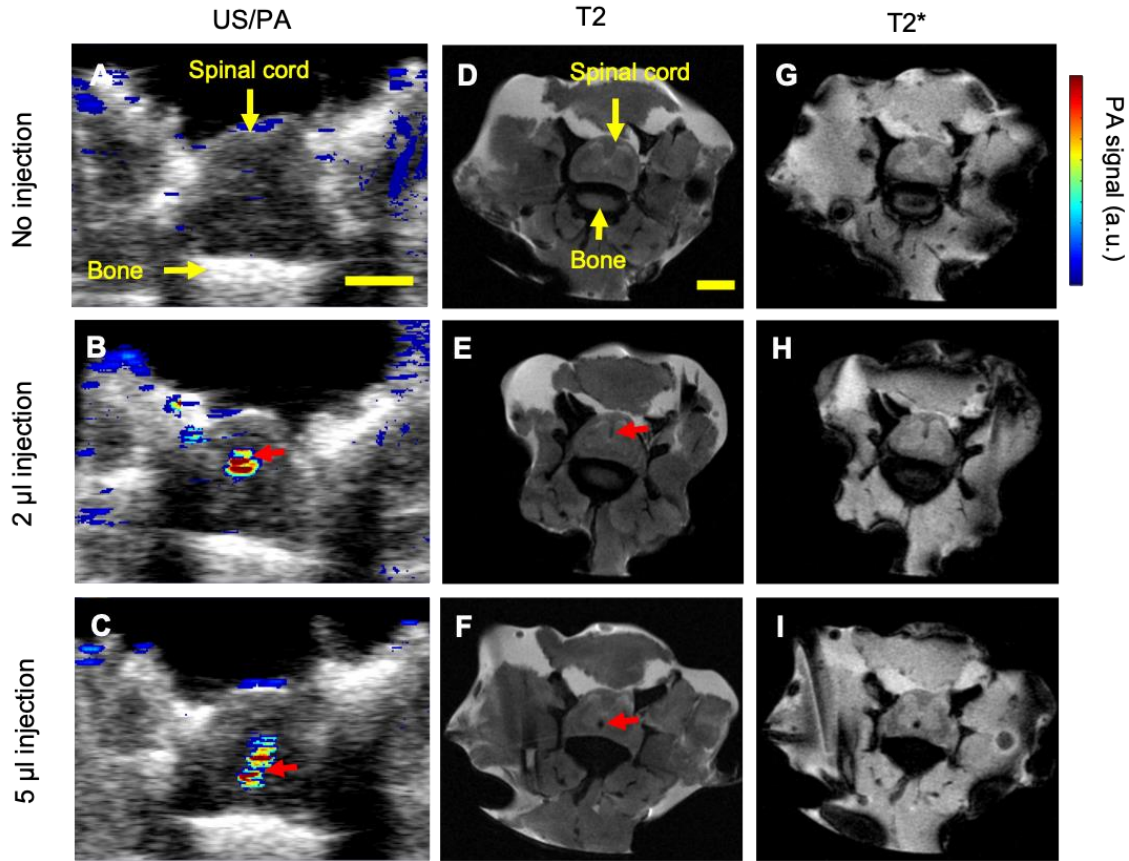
Multi-modal detection of PBNC-labeled stem cells. PBNC-labeled MSCs were suspended at 10k cells/ $\mu$ l. Top row: control, no cells injected. Middle row: 2  $\mu$ l injection of PBNC-labeled stem cells. Bottom row: 5  $\mu$ l injection of PBNC-labeled stem cells. PA images (A - C) were acquired at 740 nm wavelength. Muscle was placed over the cord prior to MR imaging to mimic the clinical procedure and the post-operative imaging scenario. MR images were acquired using T2 (D - F) and T2\* (G - I) pulse sequences. Red arrows indicate location of stem cells. Scale bar = 2 mm.
